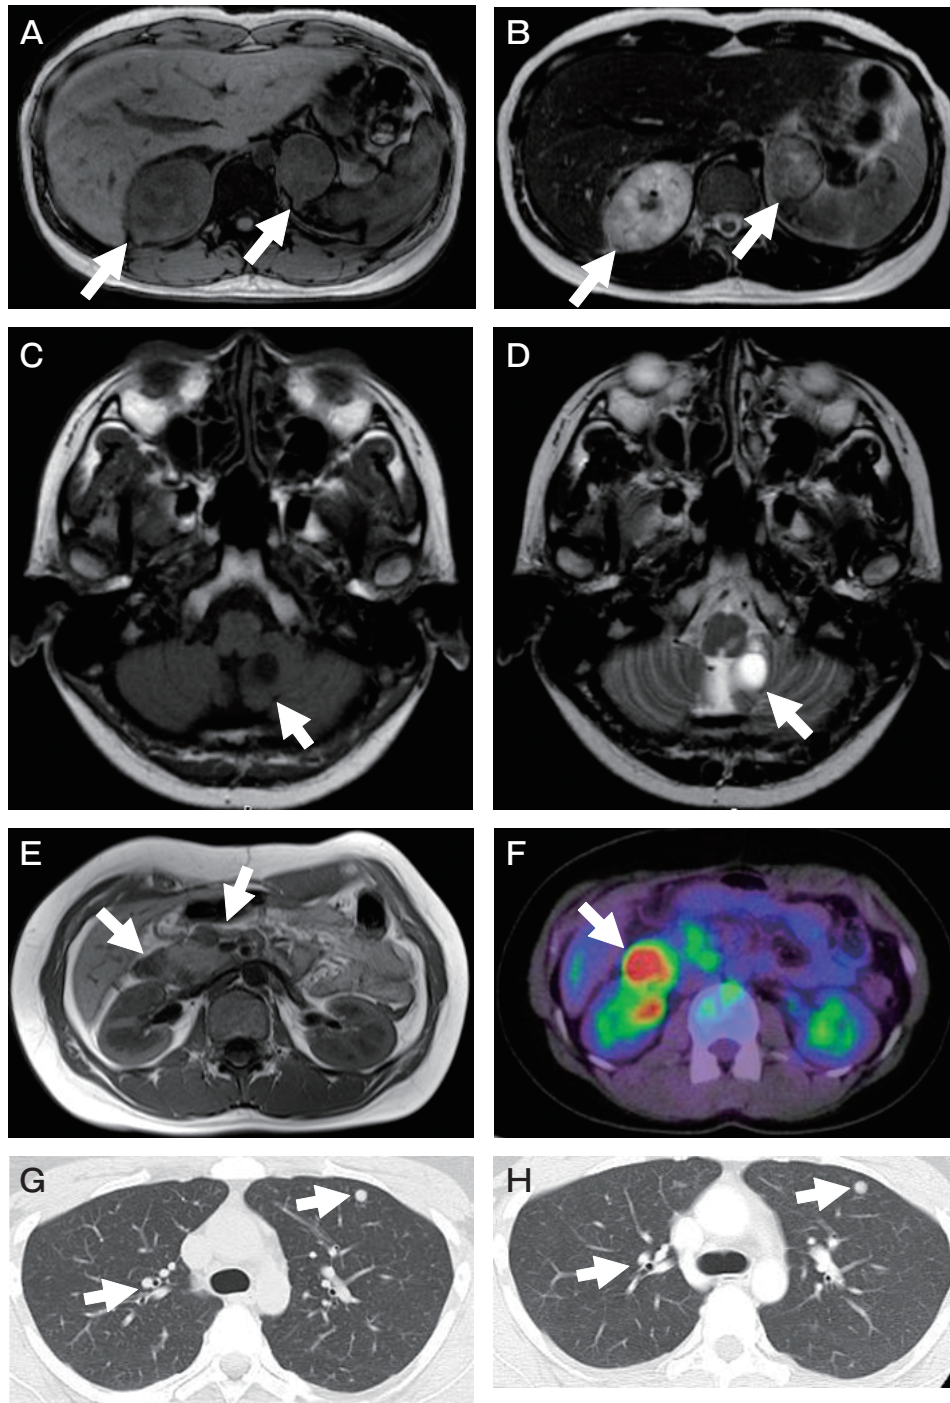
Bilateral adrenal tumors (arrows) with irregular internal structure on T1-weighted (A) and T2-weighted (B) magnetic resonance imaging at the age of 18 years; a cerebellar tonsil tumor with a cyst (arrows) on T1-weighted (C) and T2-weighted (D) magnetic resonance imaging at the age of 22 years; and multiple pancreatic tumors (arrows in E) on T1-weighted magnetic resonance imaging and abnormal uptake lesions (arrow in F, the maximum standardized uptake value: SUVmax = 13.49) on whole-body 2-¹⁸F fluoro-2-deoxy-D-glucose positron emission tomography fused with computed tomography (PET/CT) at the age of 23 years. Multiple small nodular lesions in bilateral lungs on computed tomography, metastatic from pancreatic neuroendocrine tumors, observed at the age of 23 years (G), remained stationary for one year after total pancreatectomy (H).
